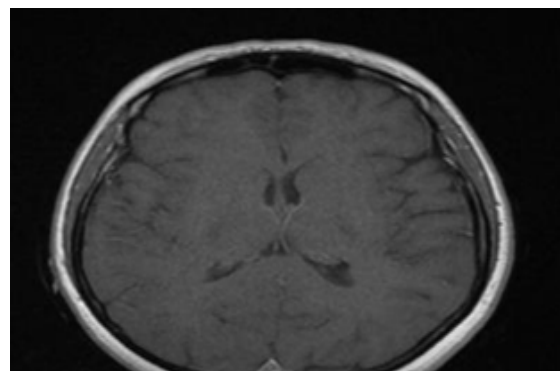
Contrast-enhanced brain MRI showing no pathological signal intensity.
